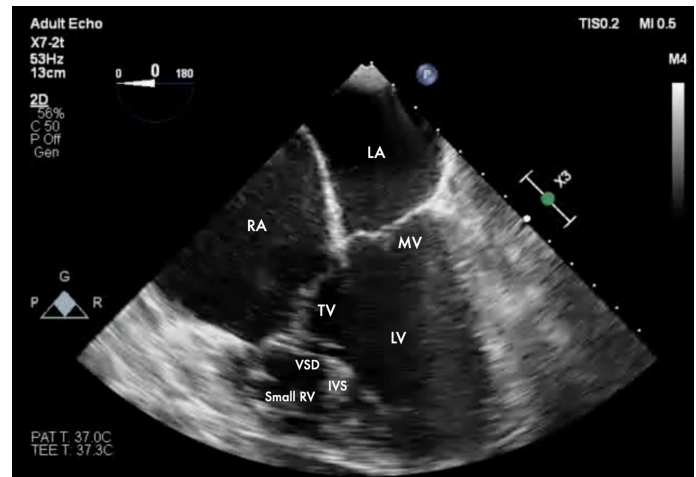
Double-inlet left ventricle in mid-esophageal four-chamber view on transesophageal echocardiography.
